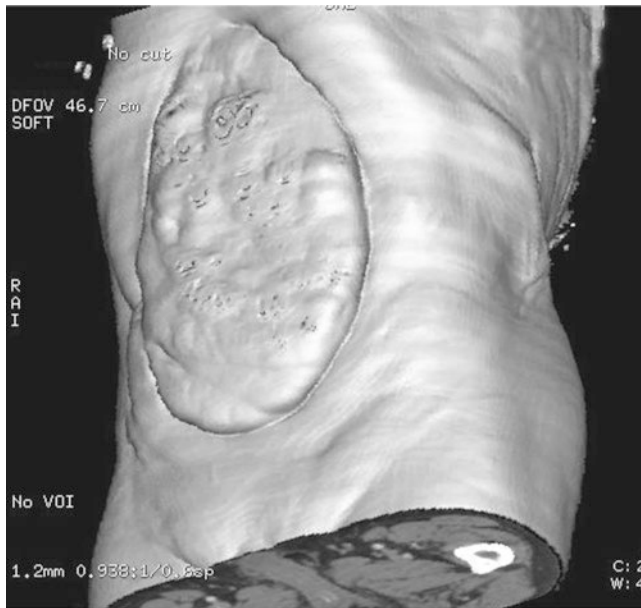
CT 3D reconstruction as a tool for pre-operative surgical technique programming
